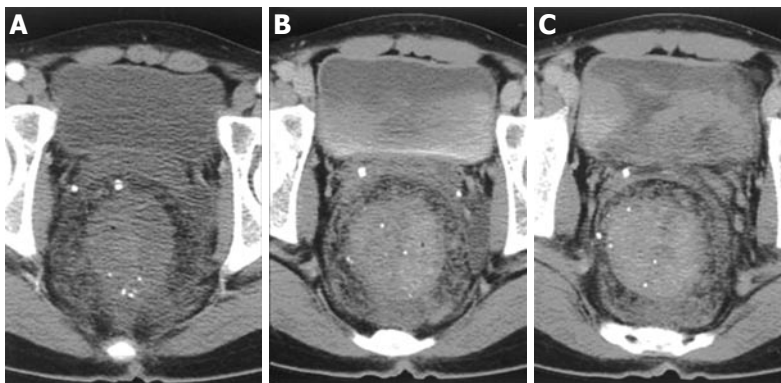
Abdomen-pelvis triphasic computed tomography showing an arterial phase image of mucosal enhancement (A) venous (B) and delayed (C) phase images of delayed diffuse wall enhancement.
